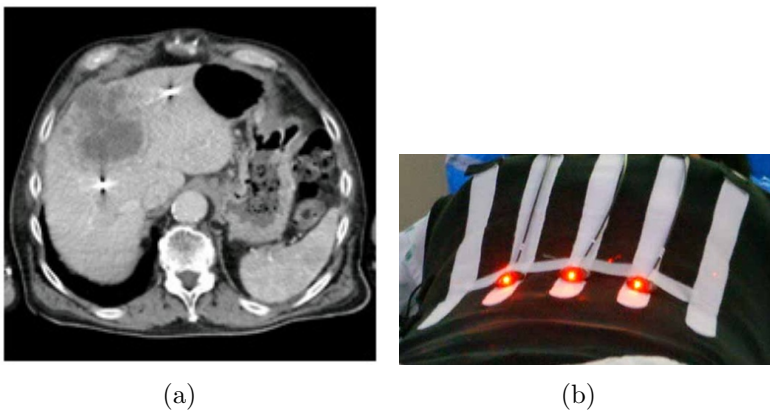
CT slice with fiducials implanted in liver (a) and infrared diodes on patient abdomen (b)
